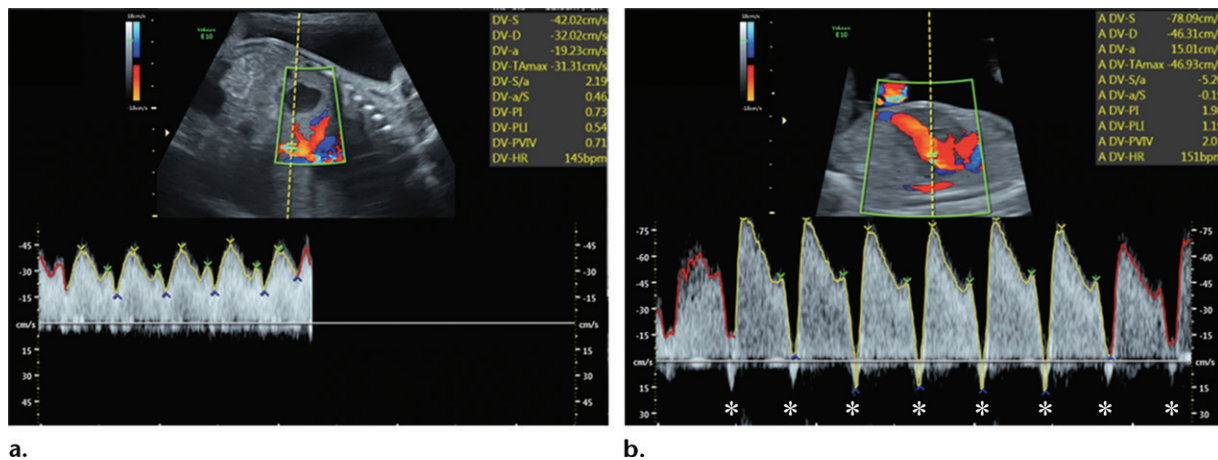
Duplex US images of the ductus venosus. (a) Oblique transverse color Doppler US image through the upper abdomen of a fetus at 30 weeks 2 days gestation shows a normal spectral waveform at the ductus venosus. Forward flow is seen throughout the cardiac cycle. (b) Midsagittal longitudinal Doppler US image of the trunk of a fetus at 21 weeks 4 days gestation shows an abnormal spectral waveform with a reversed A wave (*).
